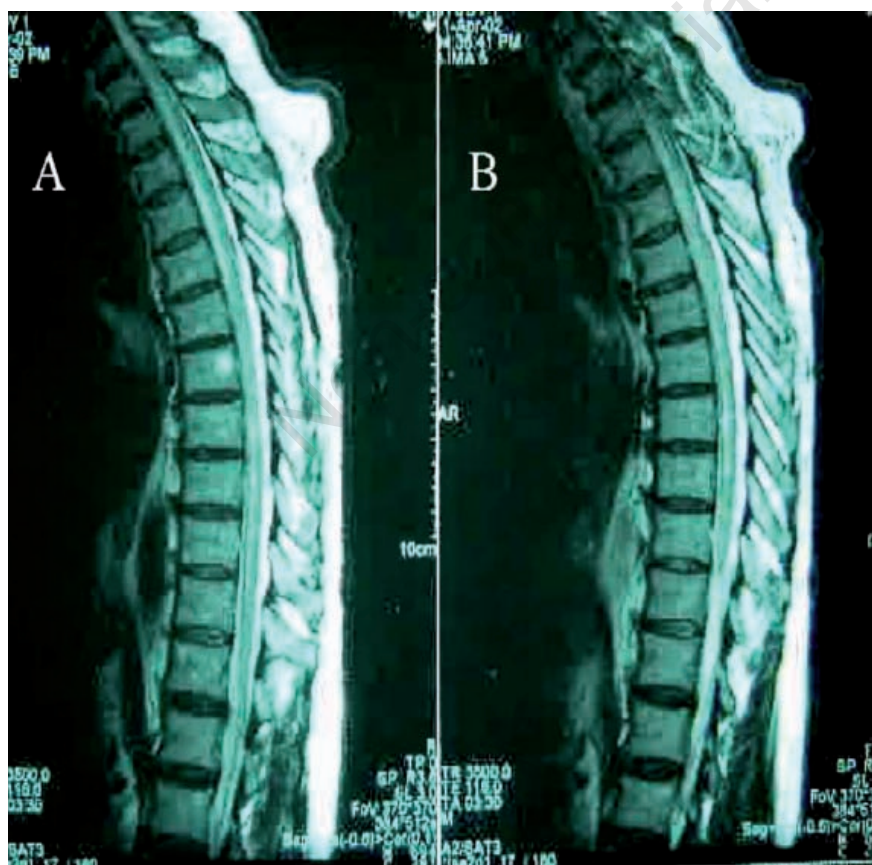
A and B Magnetic resonance image of dorsal spinal cord showing an enhanced signal in a patient presenting acute myelitis. Sagittal plane, T2 sequence.
